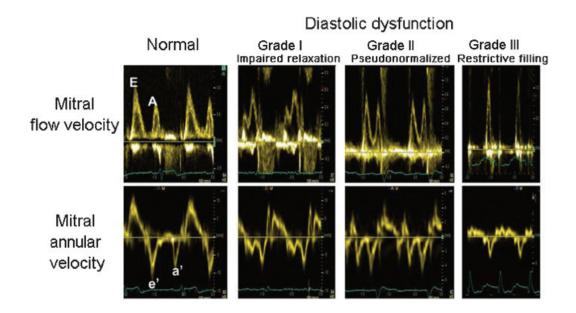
Doppler tracing in different stages of diastolic disfunction.
